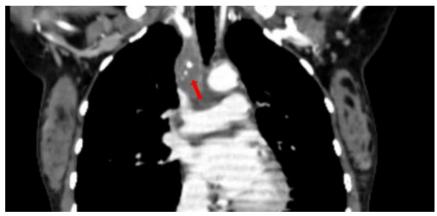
CT-Scan of Thorax, coronal view. Adenopathic conglomerate in the mediastinum, red arrow.
